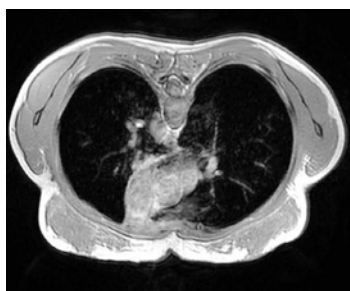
Follow up MRI of chest at 24 months shows no recurrence.
